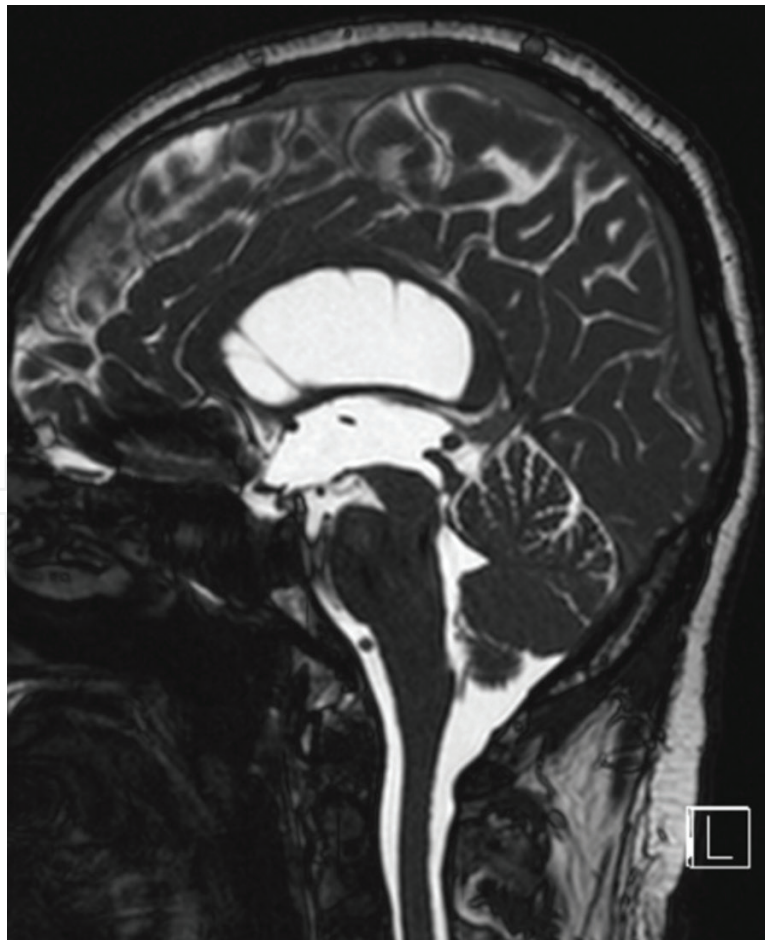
Aqueduct stenosis (MRI scan TRUF1 sequence).
